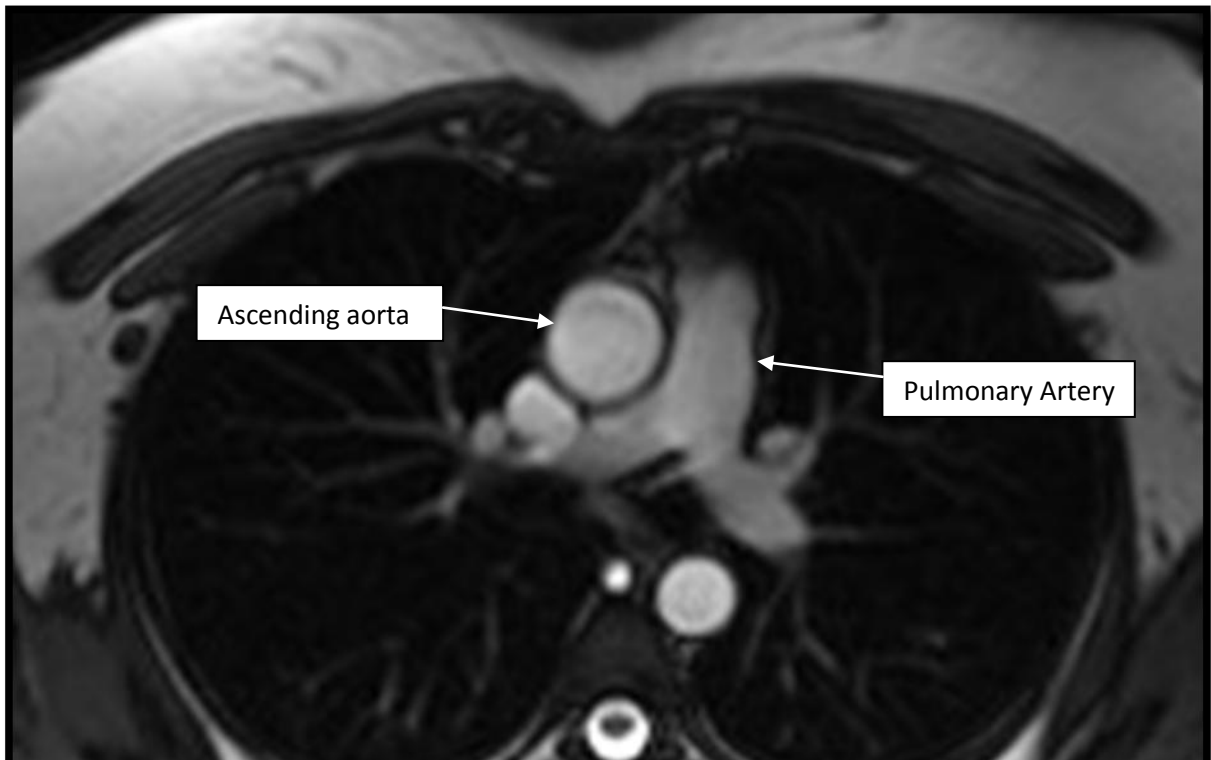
MRI TRUFISP axial sections of the chest at the level of the pulmonary artery showing normal anatomy
